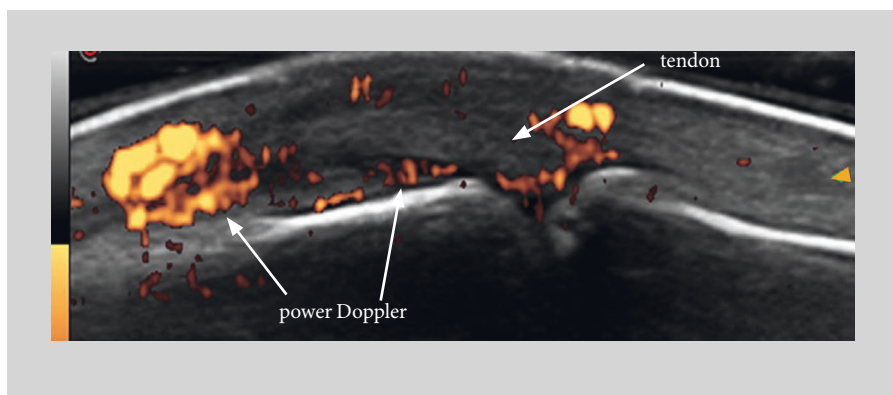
Longitudinal dorsal scan of metacarpophalangeal joint: grayscale and power Doppler ultrasound. Presence of hypoechoic synovial hypertrophy that exhibits power Doppler signal. This aspect is typical of severe synovitis.
